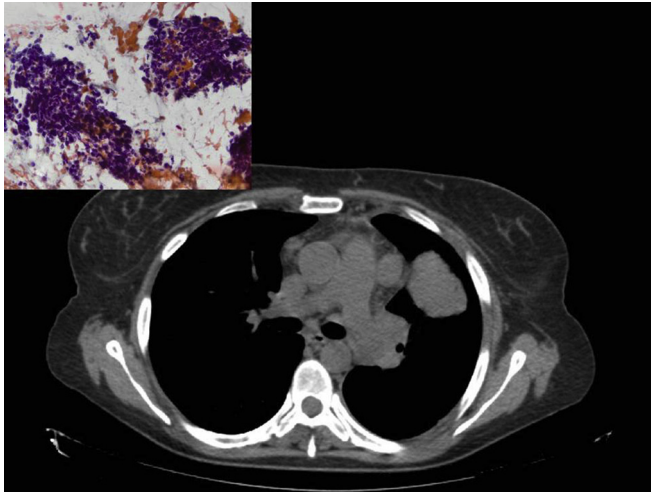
CT scan showed a mass in the upper lobe of the left lung. Inset: FNA was diagnostic for SCC (Papanicolaou x40).
